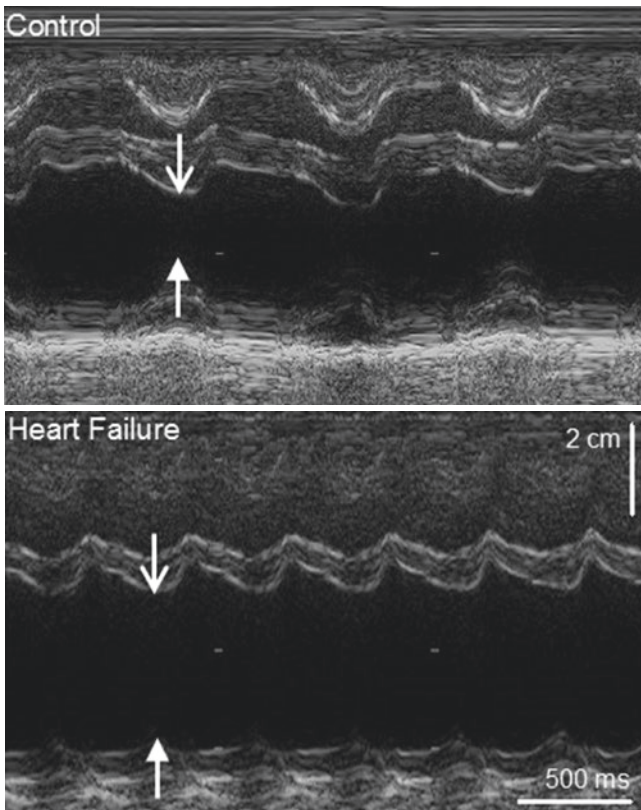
Heart failure is characterised by a drastic left ventricular remodelling; left ventricular dilation, wall thinning and reduced contractility in both the septum (*open arrows*) and free wall (*closed arrows*) can be observed using echocardiography
